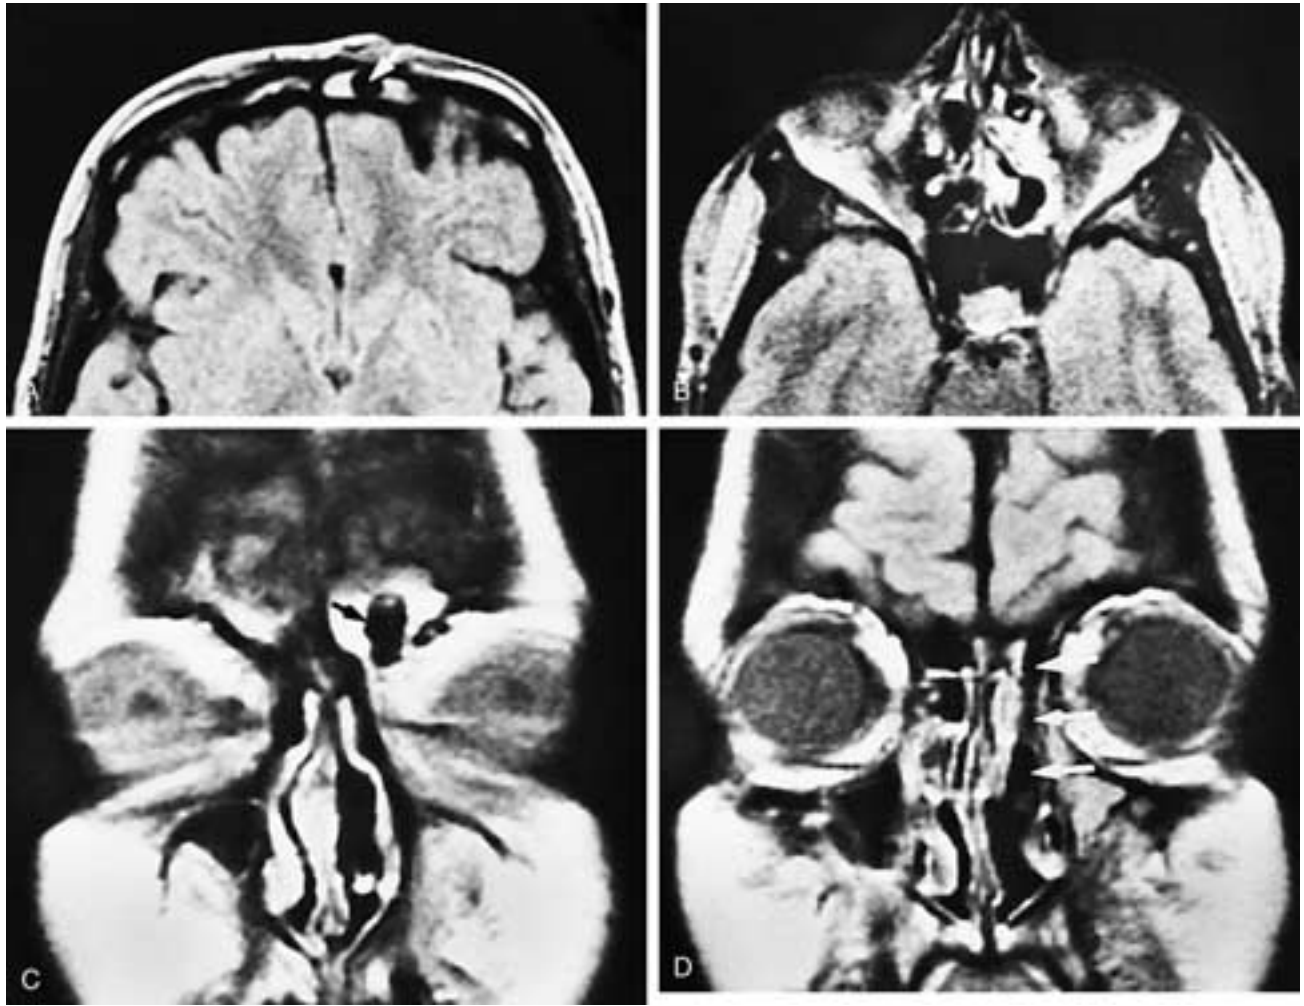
Axial proton density MR images (A, B) show a drainage tube in the left frontal sinus (A) (arrow) and sinus secretions. In (B), the drainage tube can barely be seen in the left ethmoid sinuses (arrow), and inflammatory changes are present as well. On the MR images, it is almost impossible to appreciate that an external ethmoidectomy has been performed. Coronal proton density MR images (C, D) show the tube in the left frontal sinus (black arrow) and the drainage tube extending through the ethmoid sinuses into the nasal fossa (arrows).
